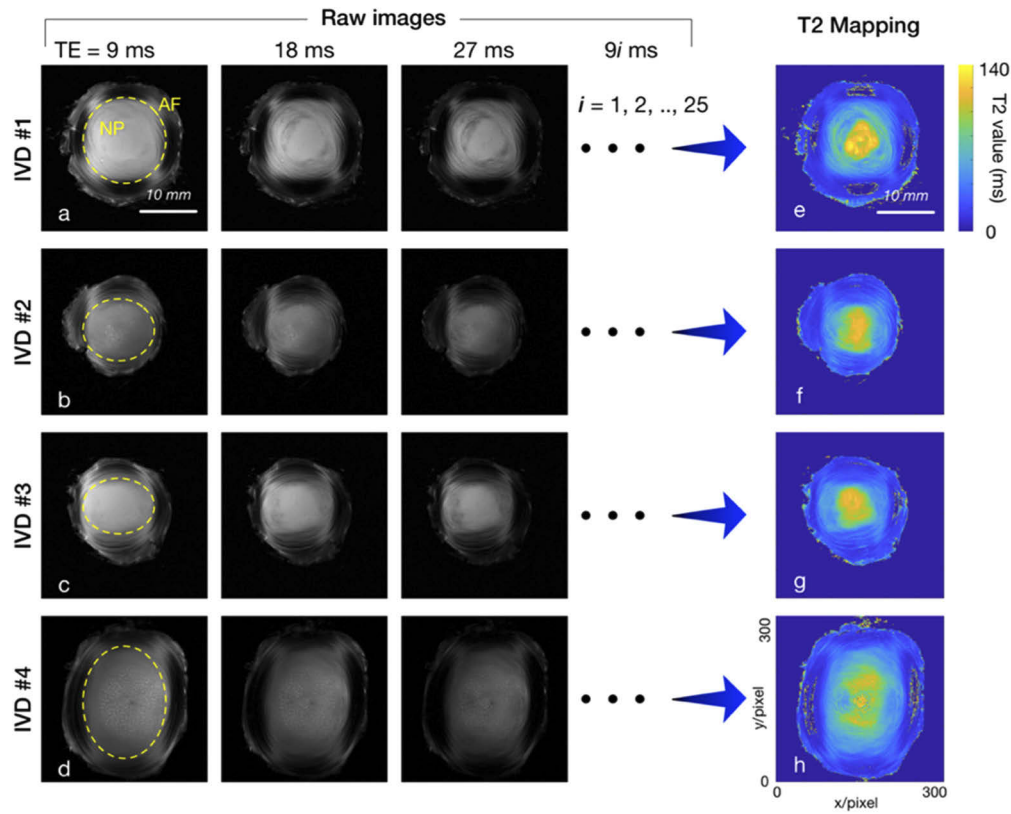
Raw T2-weighted MRI images of four IVDs are displayed on the left with a series of different TE values (a-d). Such series of T2-weighted images can yield mapping of quantitative T2 relaxation values (e-h), contributing to the evaluation of the water content inside samples. ROI inside the dashed yellow circle indicates the part of NP, while the outside represents AF. All T2 mapping images were with a threshold of 140 ms.
